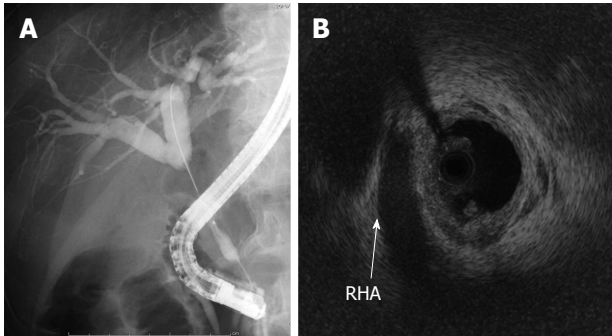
Imaging findings suggestive of bile duct cancer. A: Endoscopic retrograde cholangiopancreatography shows an irregular stenosis from superior to inferior bile duct; B: Intraductal ultrasound showing no cancer invasion to the right hepatic artery (arrow). RHA: Right hepatic artery.
